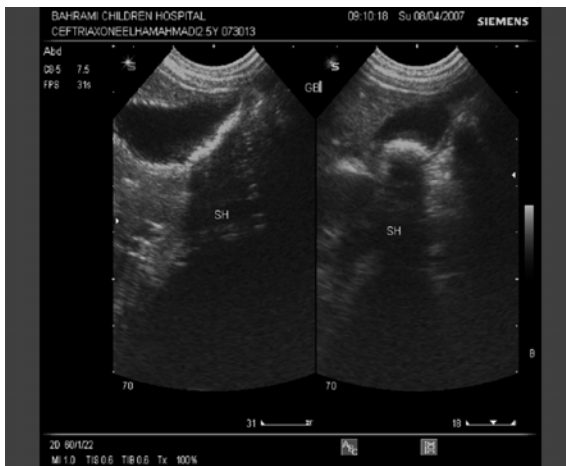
a (left)- Sonogram of case 14 showed echogenic materials with acoustic shadowing
